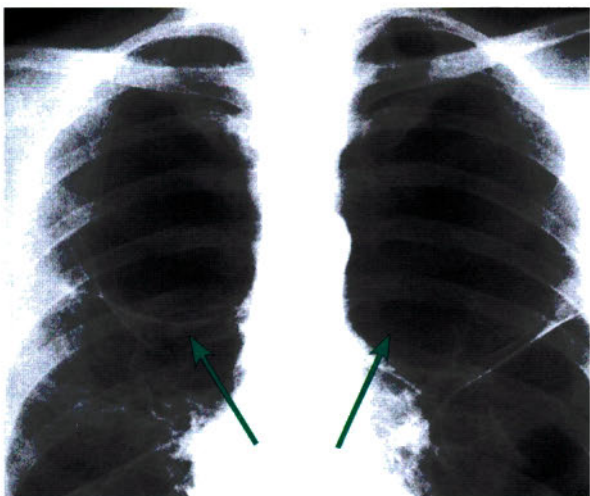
Chest x-ray showing emphysema bubbles
